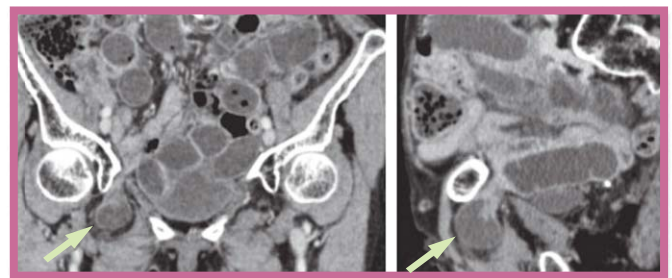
CT of the pelvis (A) coronal and (B) sagittal images showing the right obturator hernia with bowel incarceration.
